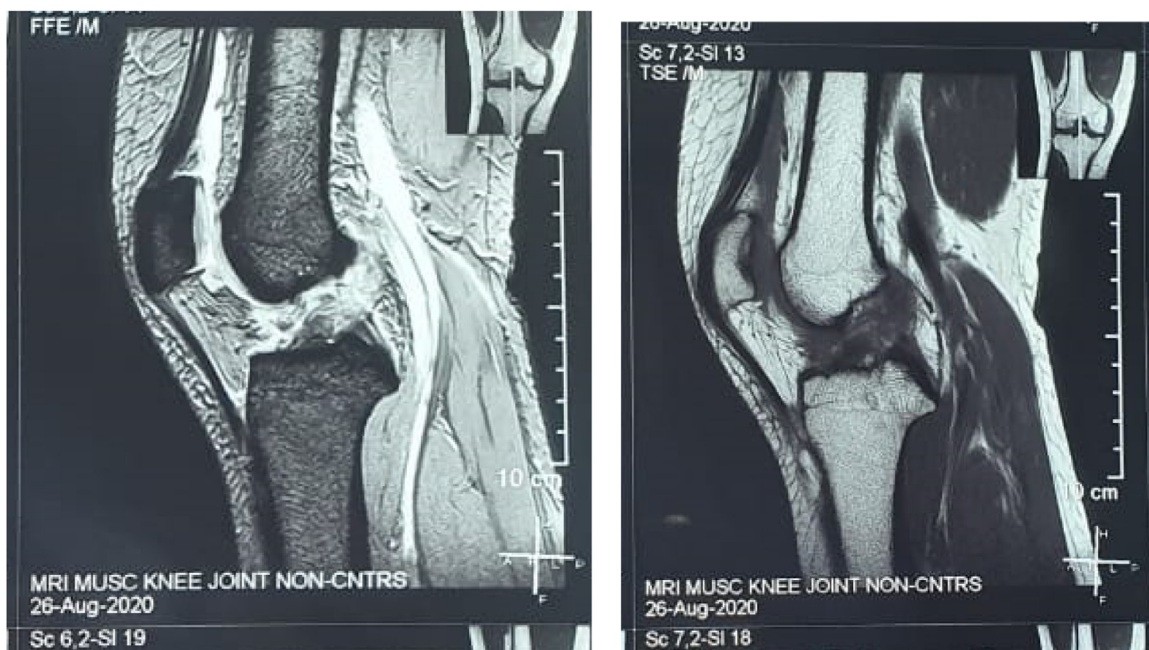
Magnetic Resonance Imaging of Knee (T1 and T2).
